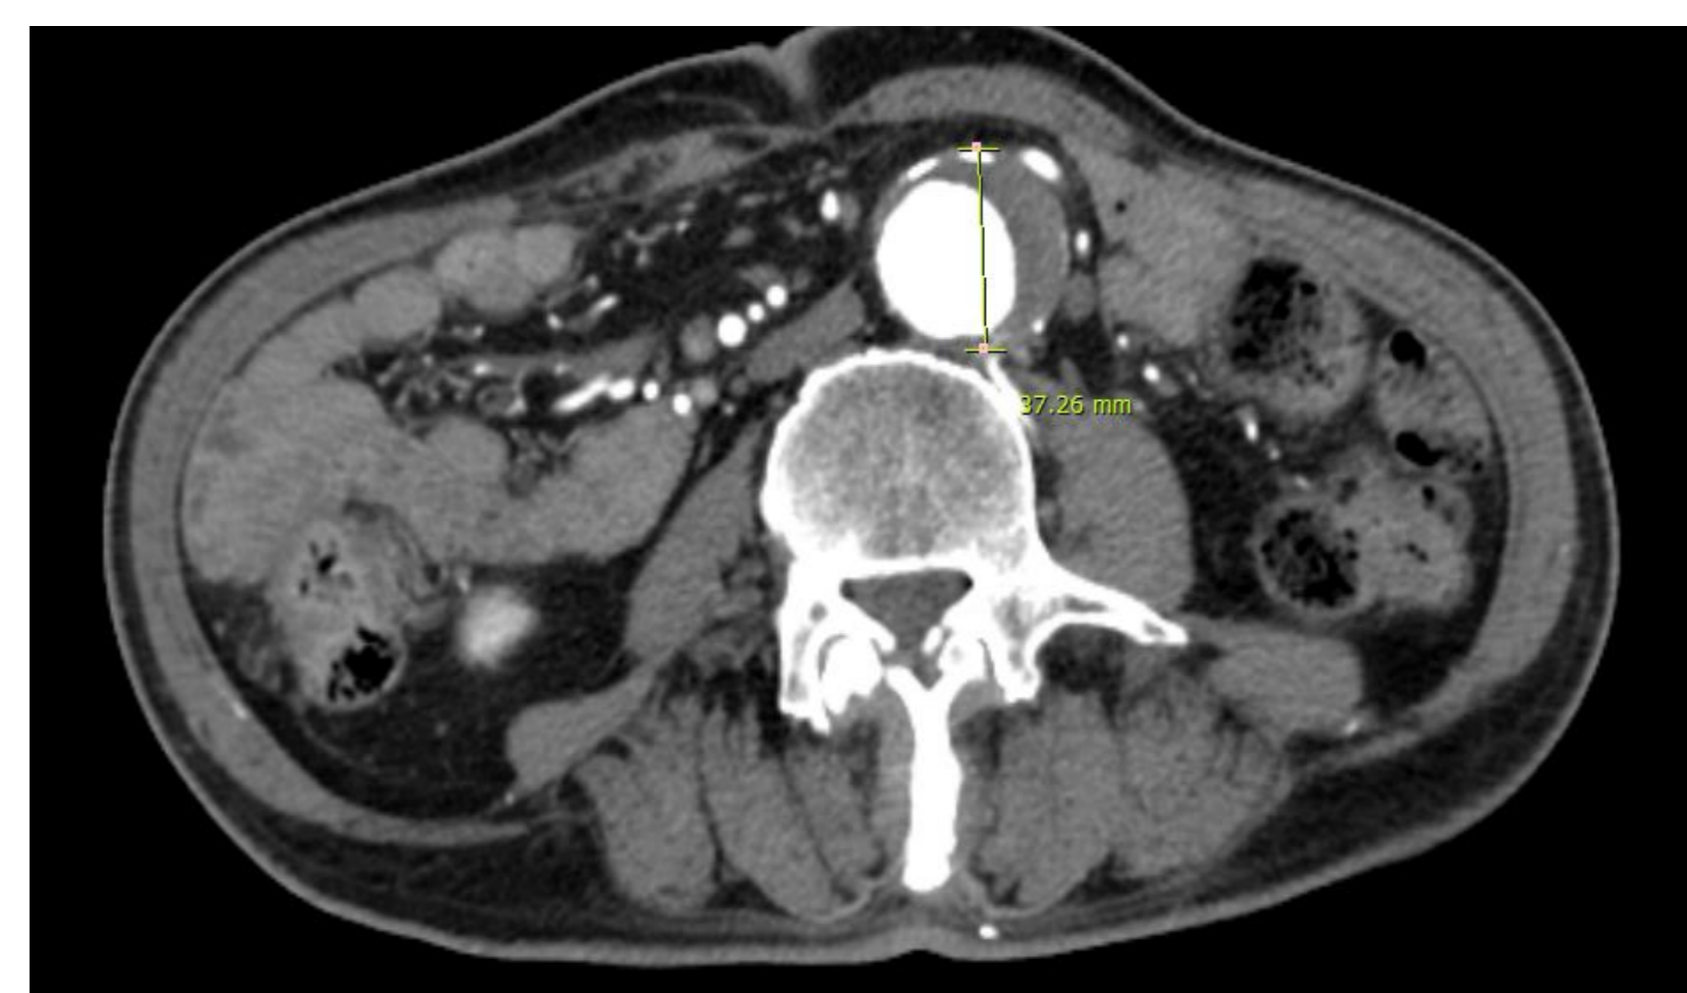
Axial abdominal CT. Aortic dissection into the abdominal aorta (37.26 mm diameter).
